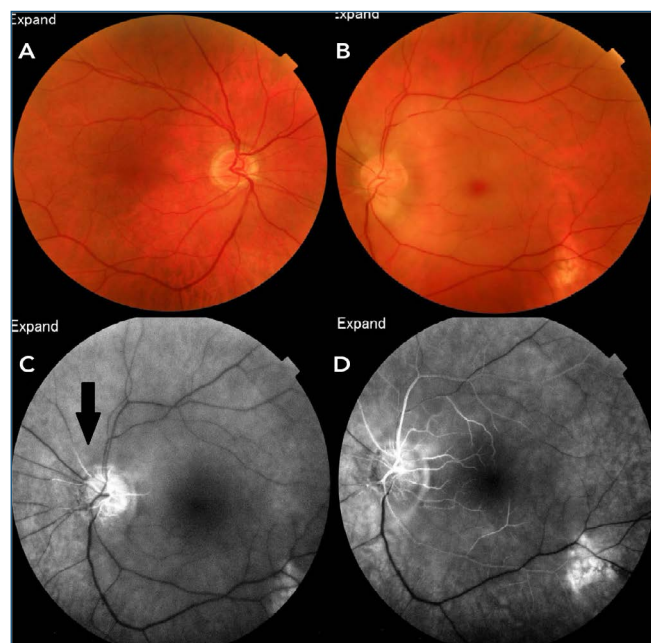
Funduscopy color images. (A) Right eye is within normal limits. (B) Left eye shows retinal pallor, a cherry fovea, and peripapillary chorioretinal atrophy and inferior temporal arcade. Fluorescein angiography of the fundus left eye revealed. (C) A delay in retinal arterial filling after choroidal flush. Areas where arteriole filling is partial and slowed suggested lumen partial obstruction (arrow). A systemic evaluation was performed, identifying a platelet count of 298,000/mm³. Serological testing for infectious organisms was unremarkable. Carotid Doppler ultrasonography revealed no abnormalities. The patient was referred for follow-up and a complete cardiovascular investigation. Clinical follow-up revealed no change in her ocular or visual condition. (D) Slow filling of the arterioles and partial filling of the veins of the superior temporal arcade.
